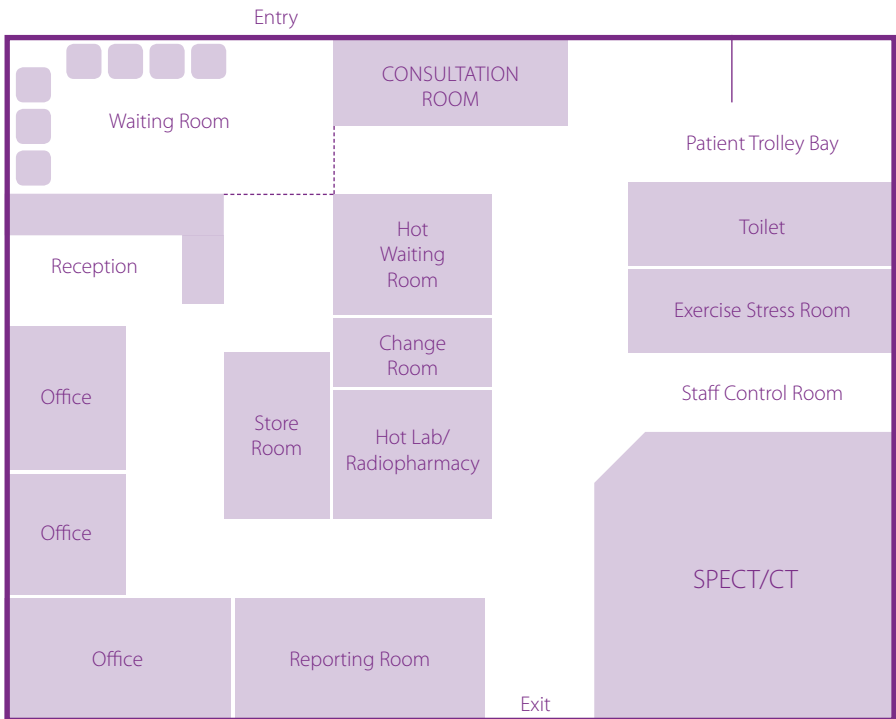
A sample floorplan for a small single gamma camera (either SPECT or SPECT/CT) that accommodates trolley bed patients and cardiac exercise stress testing
